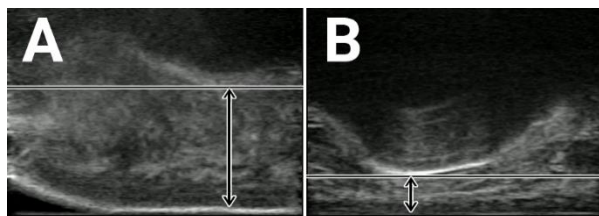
Ultrasound video outtakes: uncompressed (A) and compressed (B) heel pad. Arrows indicate HPT.
